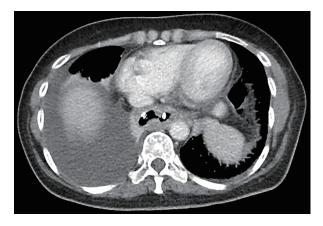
CT image, axial view, showing double J catheter in esophagus traversing through the defect with distal end in the paraesophageal collection.
